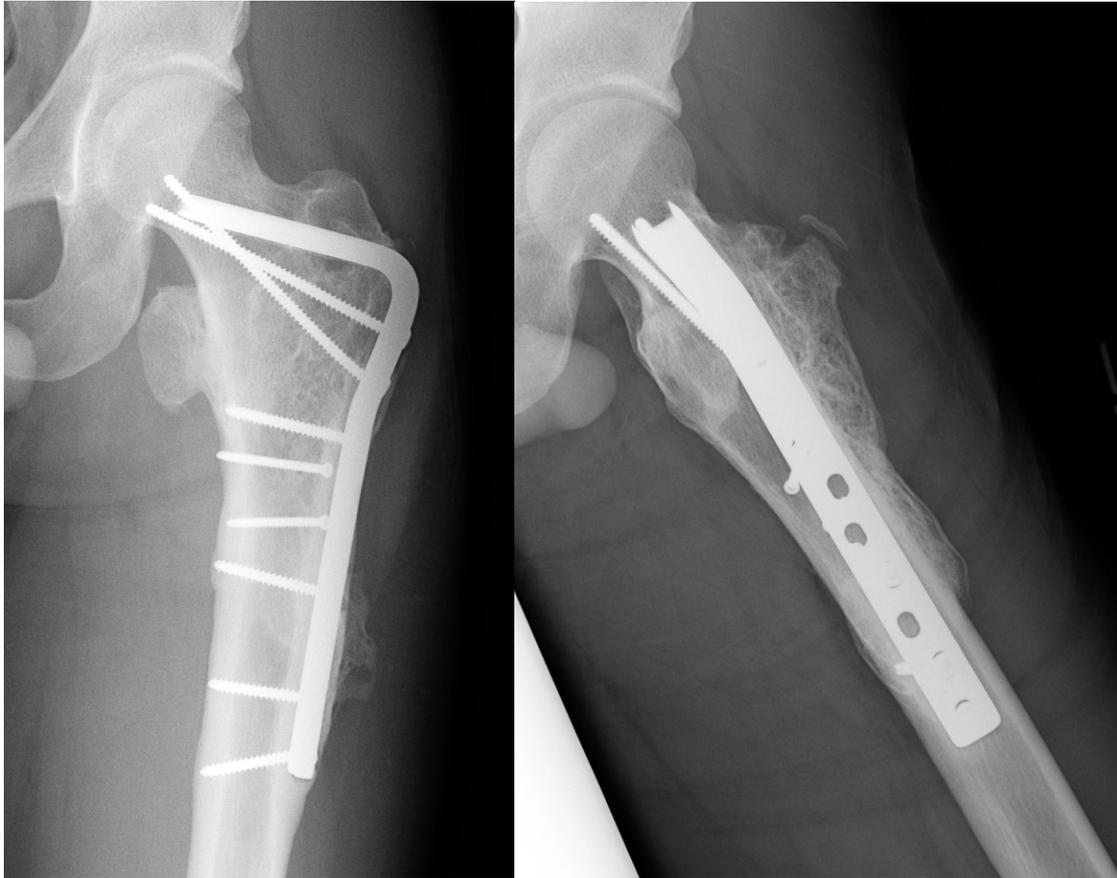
These radiographs demonstrate a healed and remodeled left pertrochanteric femur fracture 2 years after open reduction and internal fixation using an angled blade plate. He was asymptomatic with symmetrical ranges of hip and knee motions.
